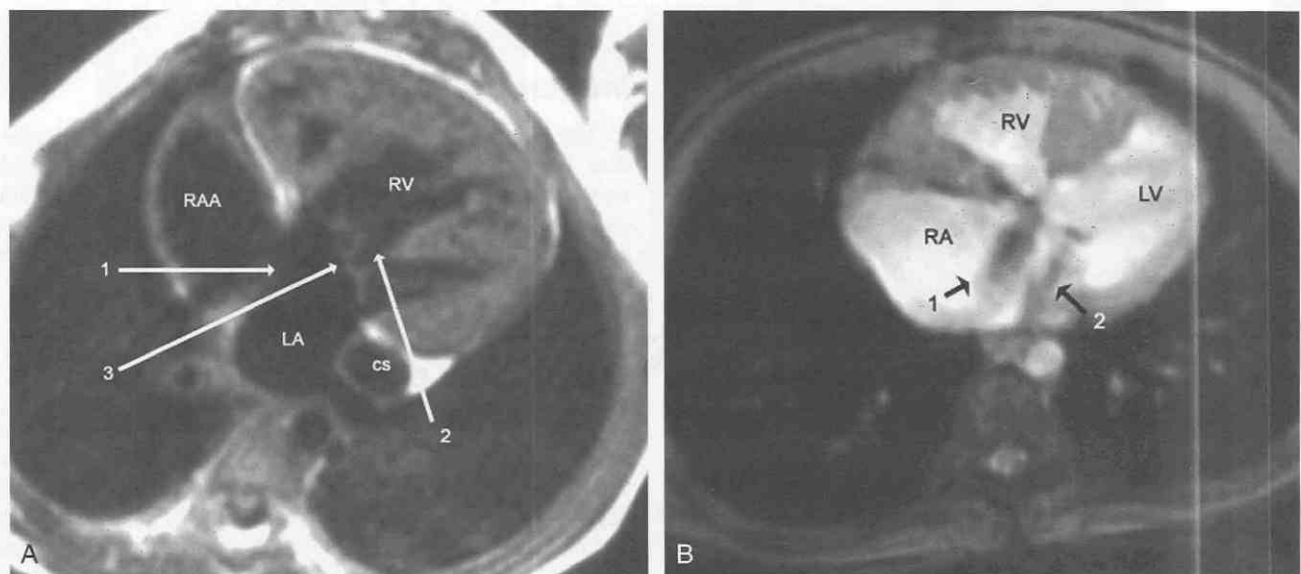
MR image obtained from two children with an atrioventricular septal defect (ASD) and a primum ASD. *A*, Axial spin-echo acquisition from a 21-month-old girl. Both the right atrial appendage (RAA) and the left atrium (LA) are dilated. There is a break in the medial aspect of the interatrial septum (arrow 1), indicating a primum ASD. In addition, there is a break in the posterior interventricular septum (arrow 2) and a solitary bridging atrioventricular valve (arrow 3). The right ventricular (RV) myocardium is severely hypertrophied. Incidentally, in this child with duplication of the superior vena cava, the left vena cava drains to the dilated coronary sinus (CS).
